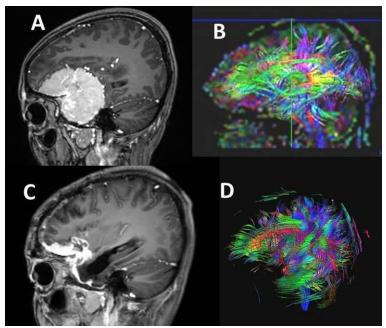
MRI and Diffusion Tensor Imaging (DTI) for one of the studied patients. A and B: MRI and DTI prior to surgery and C and D, the MRI and DTI after the surgery. Marked improvements are noted in anatomical as well as in tensor strength.
